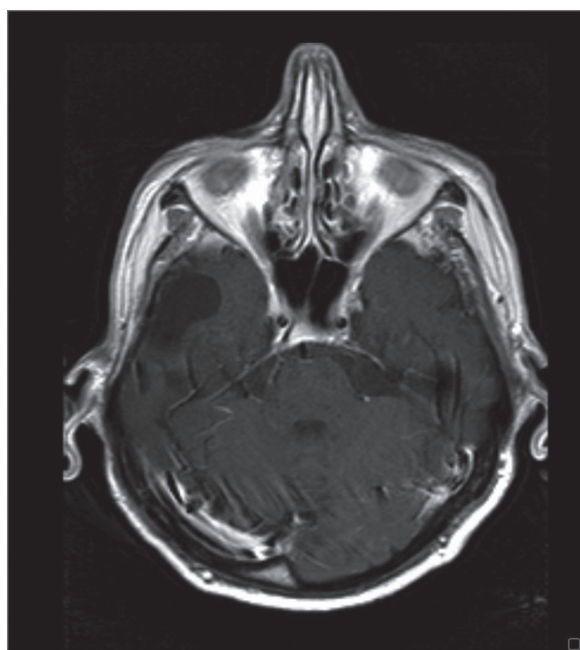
Last follow-up MRI — seven years after treatment. Axial T1-weighted image. Postoperative fluid-filled site in the right temporal lobe
